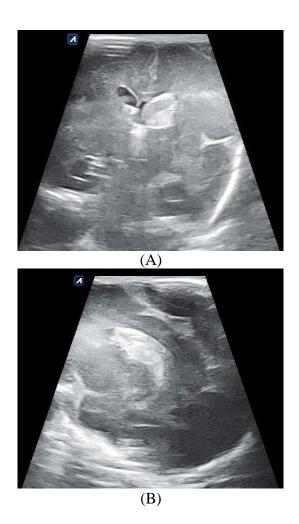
Preterm newborn male with HIE grade-III scanned at <36 hrs. (A) and (B) Coronal and sagittal view of cranial ultrasound showing germinal matrix hemorrhage extending into the ventricles (Grade-II)
